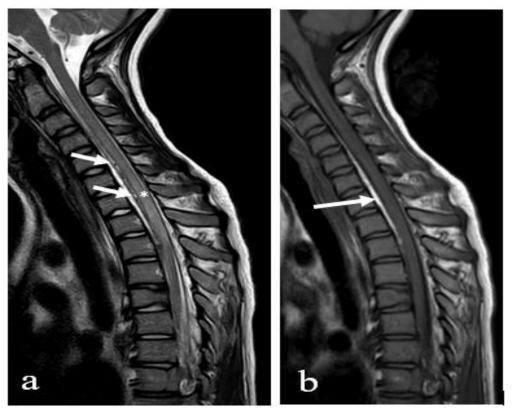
MRI of the cervicodorsal spine a) Sagittal T2 WI image showed increased cord signal (asterisk) likely congestive myelopathy with multiple engorge vessels (arrows) (b) Sagittal T1WI showed small epidural hematoma (long arrow) exhibiting bright signal.
